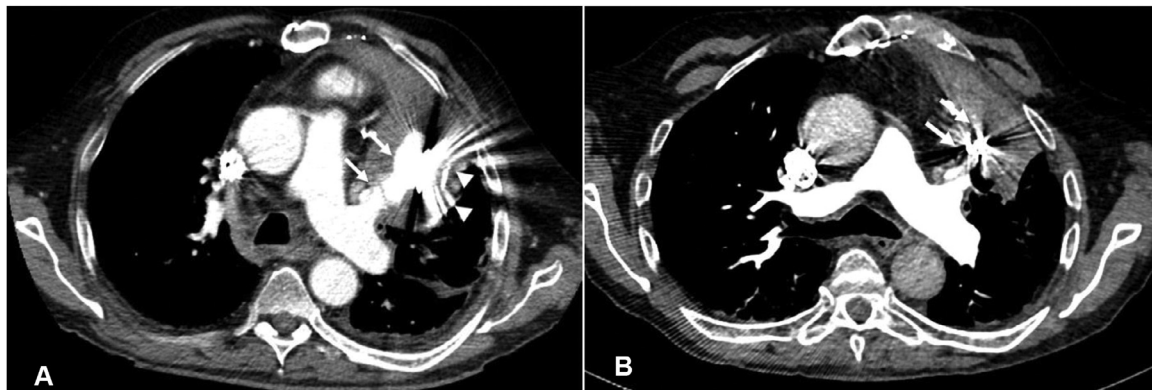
(A) An 8 cm irregularly margined, partially thrombosed pseudoaneurysm of the left upper lobe pulmonary artery (arrows), located immediately deep to the epicardial defibrillator patch on the left lateral margin of the heart (arrowheads). (B) Post percutaneous coiling CT chest showing a completely thrombosed left pulmonary artery pseudoaneurysm (arrows).
